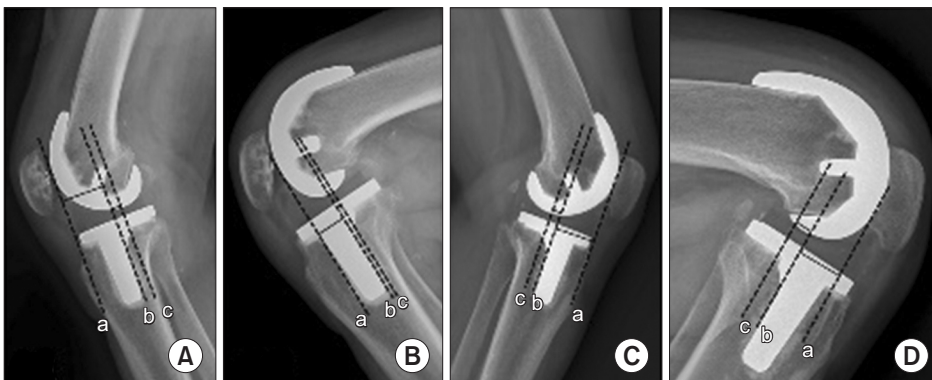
Indirect femoral rollback assessment on 30° flexion (A, C) and active deep flexion (B, D) lateral radiographs. a: femoral component anterior margin, b: deepest point of polyethylene, c: most posterior contact point.
